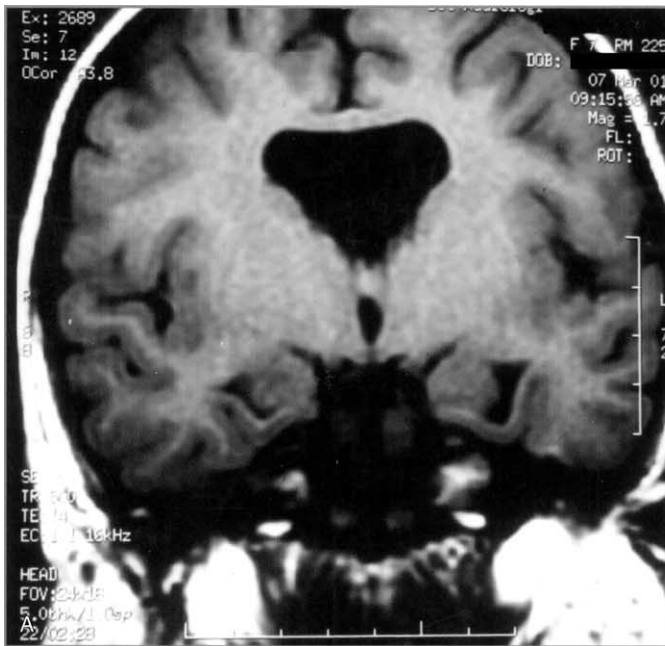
(A) Coronal  $T_1$ -weighted magnetic resonance image (TR, 500; TE, 14 ms) of the brain reveals complete absence of the septum pellucidum with a single ventricle and fusion of the columns of the anterior fornix which project into the former cavity of the third ventricle. (B) Sagittal  $T_1$ -weighted magnetic resonance image (TR, 400; TE, 15 ms) of the brain reveals a small pituitary gland with hypoplastic optic nerves (pointed arrow) and optic chiasm (arrow).
